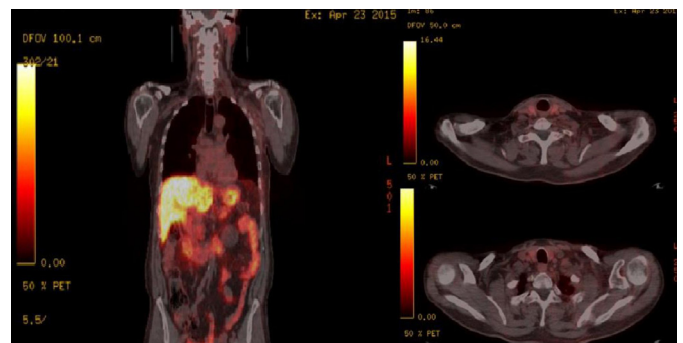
Ga68 PET/CT scan – Post Chemoradiotherapy showing complete response.
